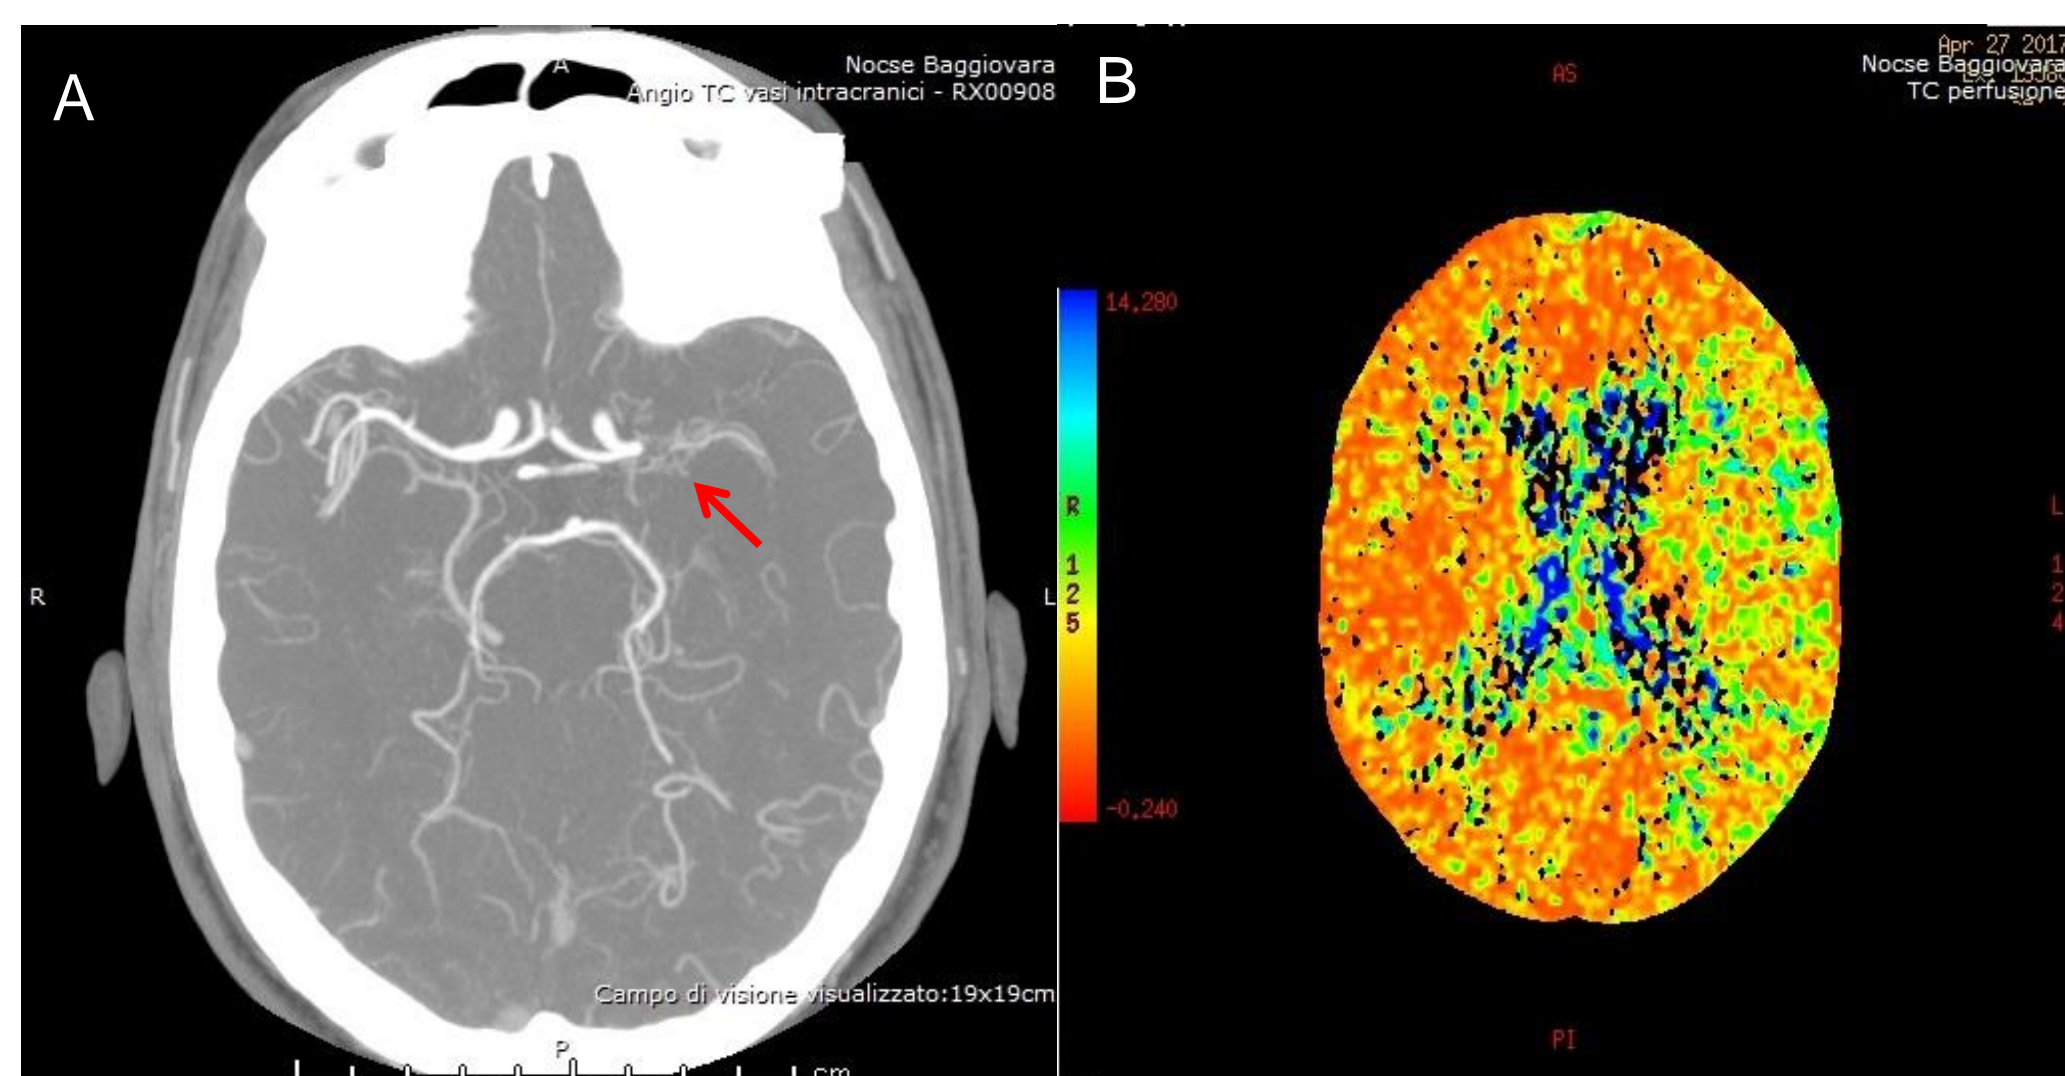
A) CT angiography shows proximal left middle cerebral artery occlusion with abnormal collateralization (arrow). B) CT perfusion shows left middle cerebral artery territory hypoperfusion in MTT map (increased mean transit time).
